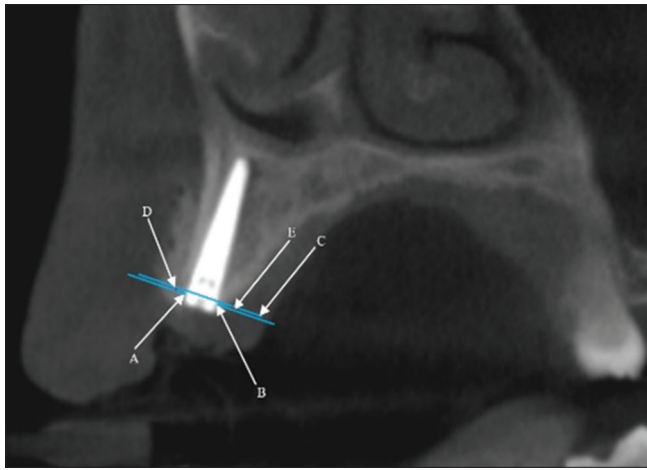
CBCT MARGINAL bone-level determination. (A) Bone crest buccally, (B) bone crest lingually, (C) line passing through implant shoulder buccolingually, (D) vertical distance between A and C, (E) vertical distance between B and C
